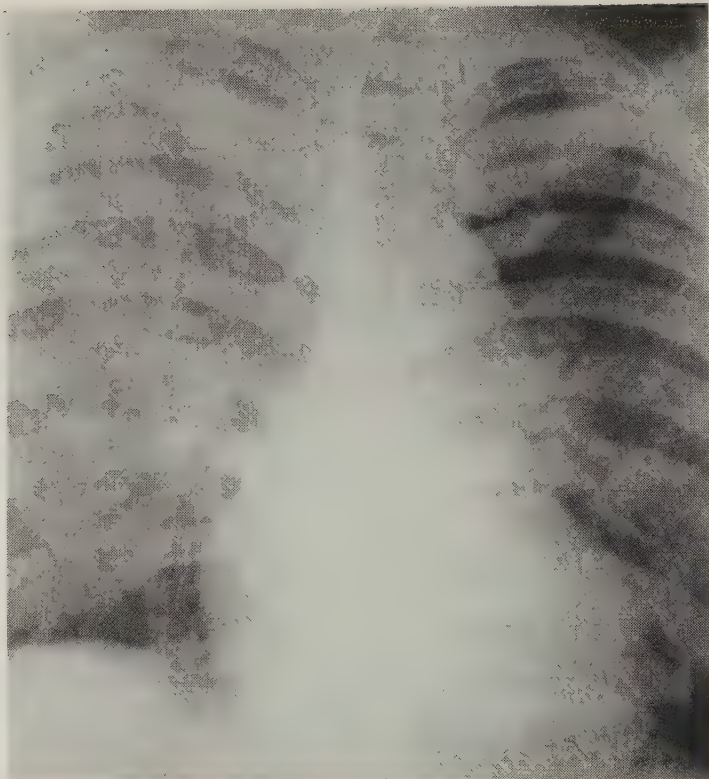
Shown is a case of lobar pneumonia, right lower lobe, roentgenogram made on admission, October 16, 1957. (Case 5.)
